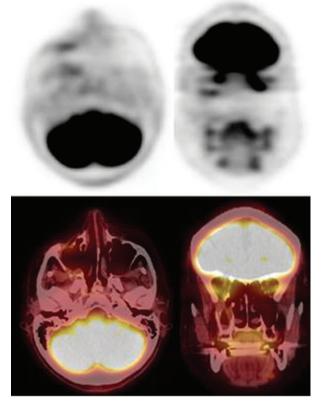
Positron emission tomography (top) and positron emission tomography/CT fusion (bottom) images following exploration and drainage of infection. The area of increased uptake is markedly reduced, with a slight decrease in metabolic activity (standard uptake value = 6.53).
